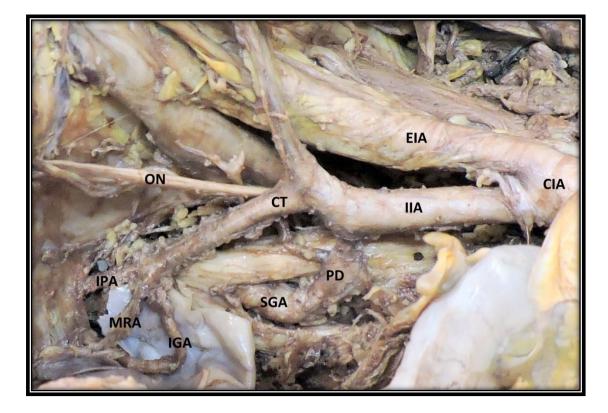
Left pelvic half shows the origin of middle rectal artery (MRA) from a common trunk (CT) with internal pudendal artery (IPA) & inferior gluteal artery (IGA). IIA: Internal iliac Artery; CIA: Common iliac artery; EIA: External iliac artery; SGA: Superior gluteal artery
